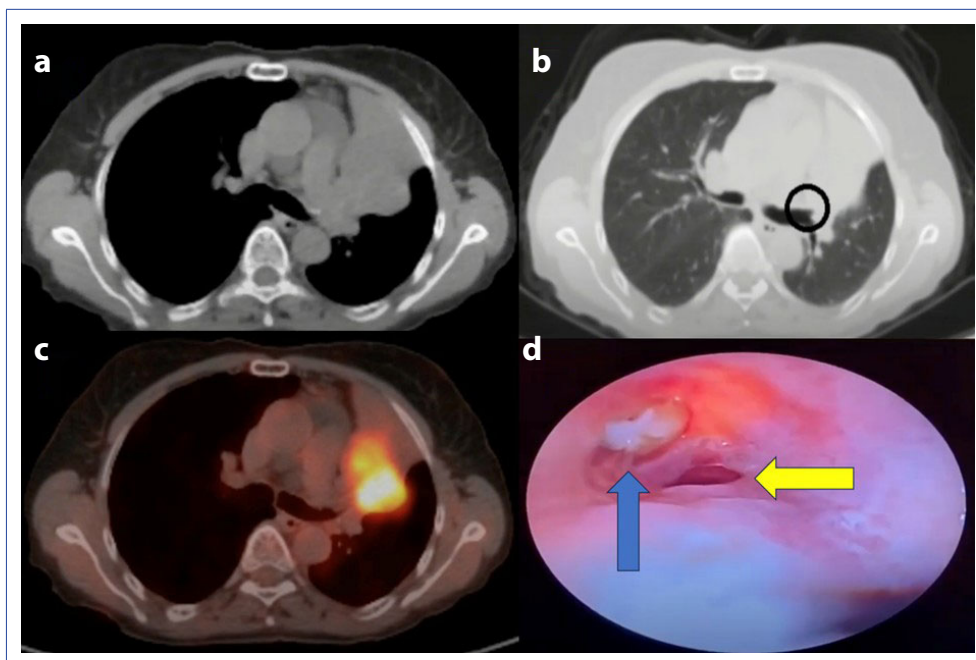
Radiological and bronchoscopic findings. a. The mass is close to the pulmonary artery, b. Atelectasis due to complete obstruction of the left main bronchus by the mass, c. High SUVmax retention of the mass in PET-CT, d. Image of the mass from the left main bronchus entrance with fiber optic bronchoscopy. Blue: left upper lobe bronchus Yellow: left lower lobe bronchus.
